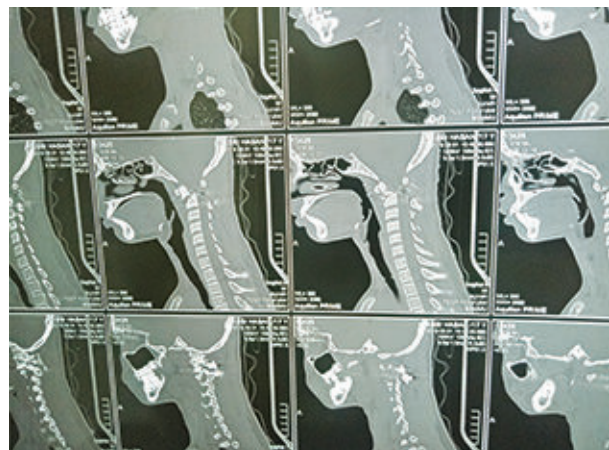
CT scan of cervical spine with OS odontoidium
